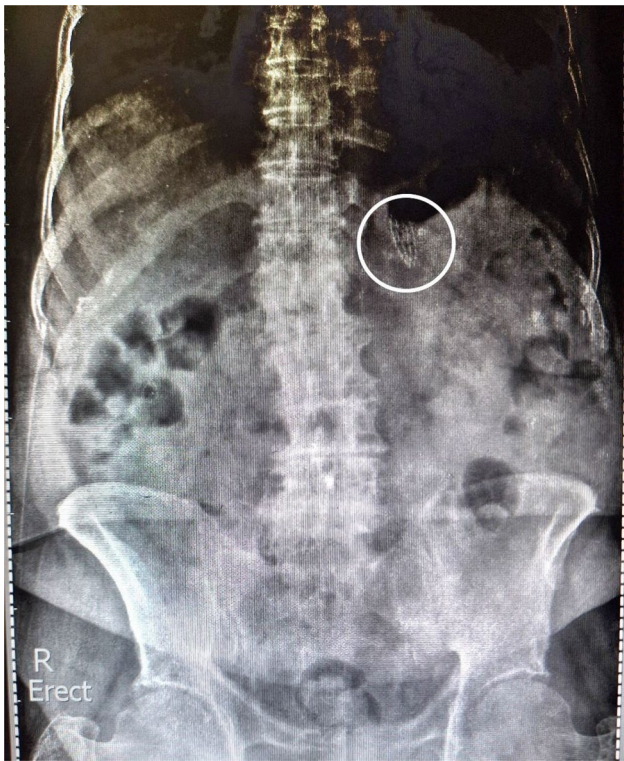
X-ray of abdomen showing radio-opaque bristled end of tooth brush (circled)
